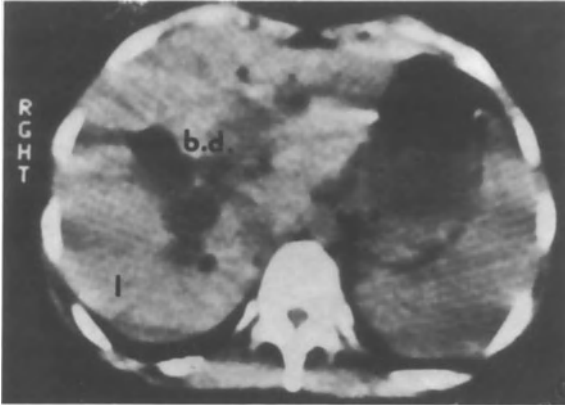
Computed tomography reveals segmental cystic dilations of intrahepatic bile ducts (Caroli's disease). Verified by surgery. (Heger).
